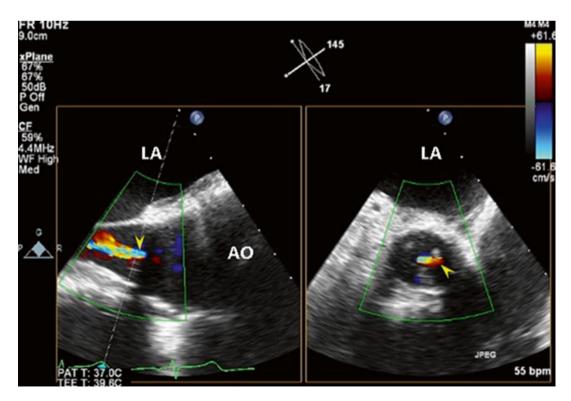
2D TEE color Doppler, x-plane view, status post David's operation, showed mild AR (arrows)
